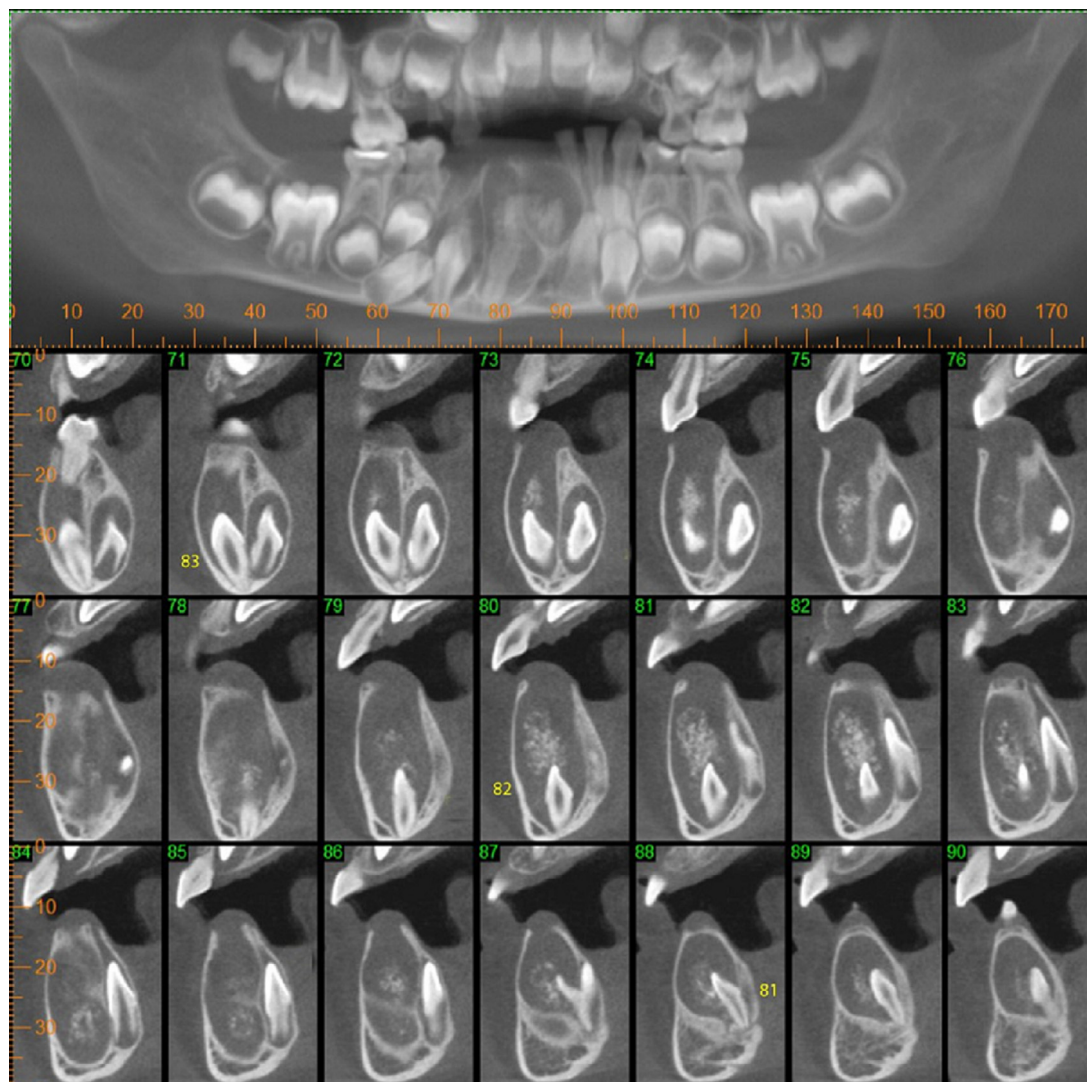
Computed tomography (CT) scans showing adenomatoid odontogenic tumors in the mandible. Multiple unilocular and well delimited hypodense areas with hyperdense foci associated with nonerupted primary teeth #81, #82, and #83 are observed. Impacted permanent teeth #41, #42, and #43 were located between the tumors and the lingual cortical plate.
